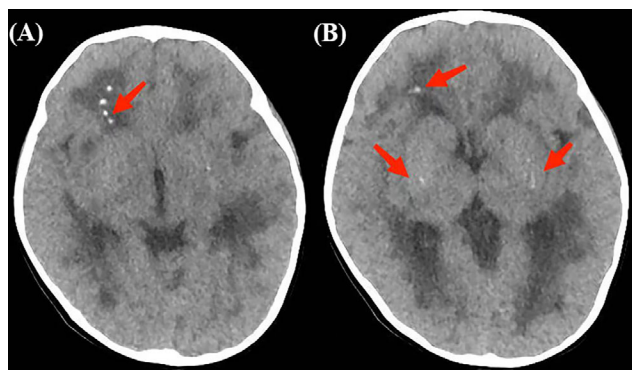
Computed tomography findings in Patient 15. Computed tomography showed spot calcification (red arrows) of basal ganglia (A), frontal lobes, and parietal lobes (B).
